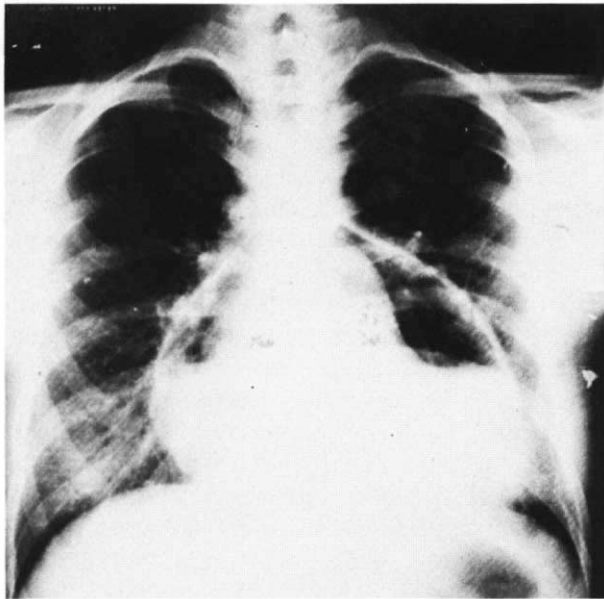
Chest radiograph showing intrapericardial air injected after pericardiocentesis.
